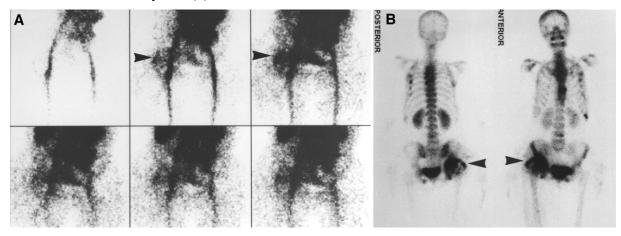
Three phase bone scintigraphy of HO
